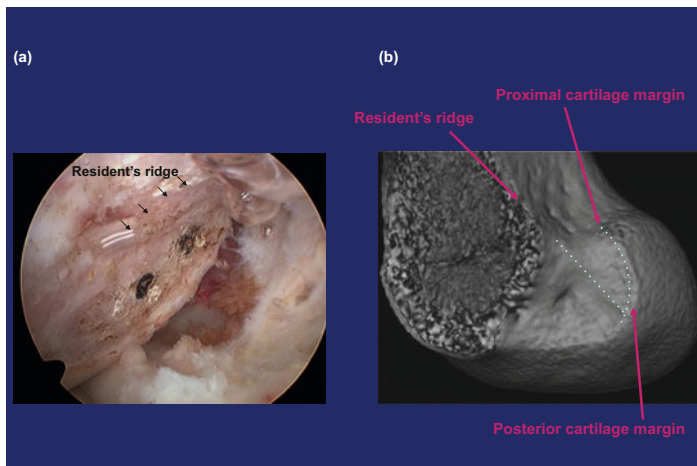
ACL femoral attachment area of the *right* knee. (a) Arthroscopic view via the anteromedial portal with a 45° arthroscope; (b) 3D CT view. There are three landmarks to identify the attachment area: resident's ridge, *proximal* cartilage margin, posterior cartilage margin
